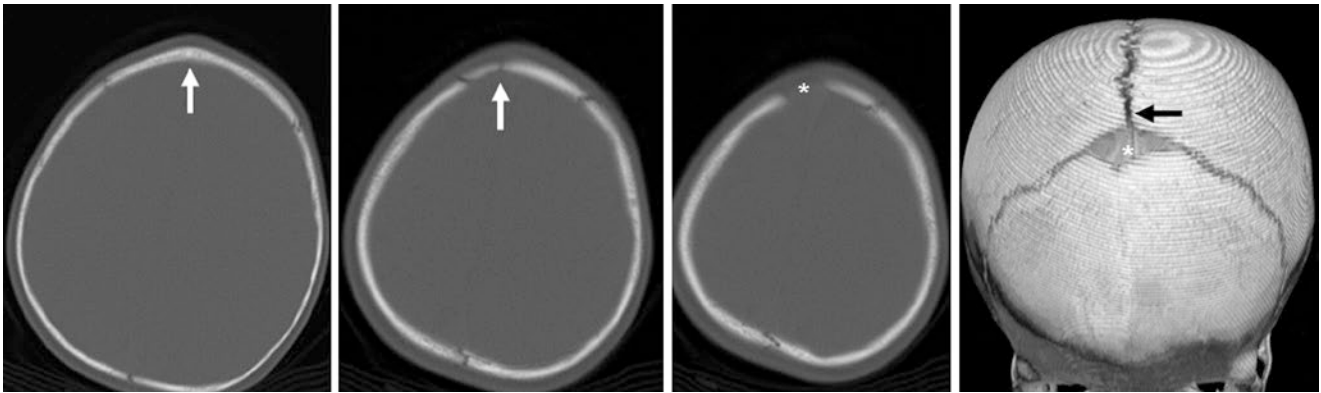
A 9 month old with an asymmetric, small AF (*) and a short, residual portion of the MS (arrows). Note the sagittal suture (black arrow) on a 3D VR CT (right, anterior view)
